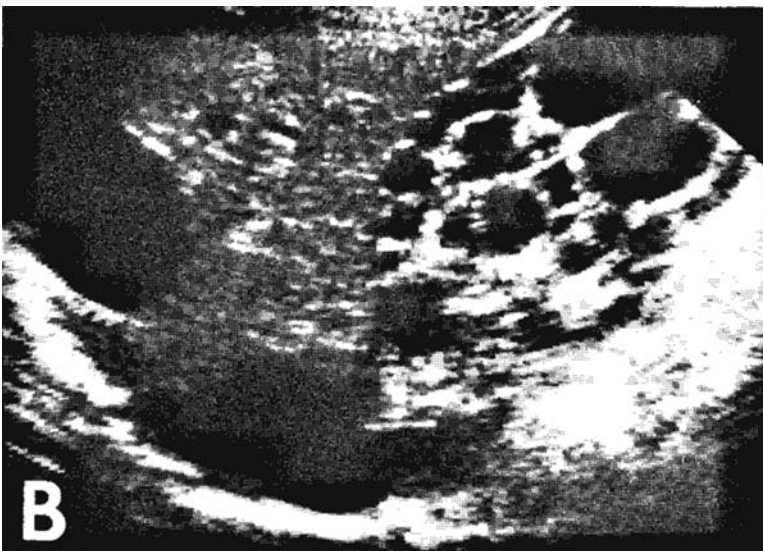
Ultrasound scan of ADPKD kidneys.
